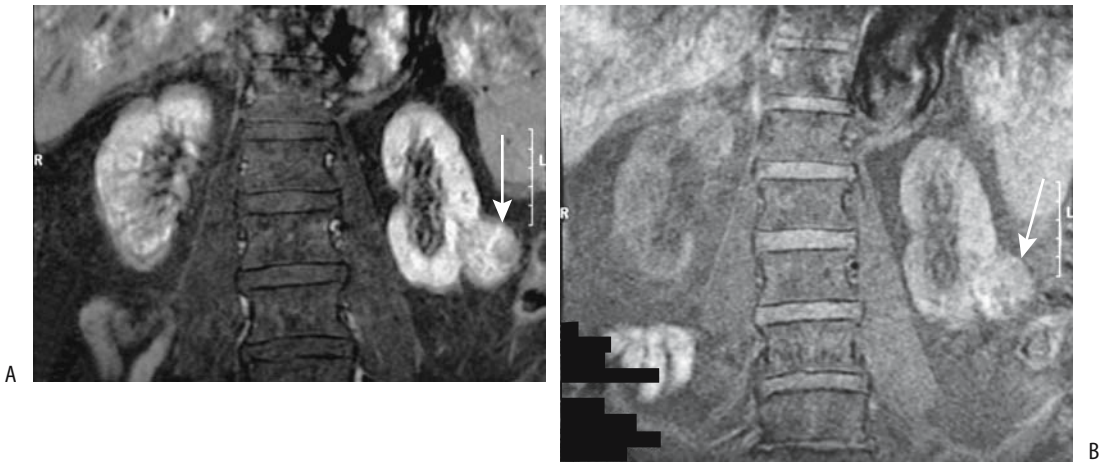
Left renal cell carcinoma. Pre- (A) and postcontrast (B) T1-weighted coronal MR images using fat suppression reveal a heterogeneous renal tumor (arrow). (Courtesy of Patrick Fultz, M.D., University of Rochester.)
